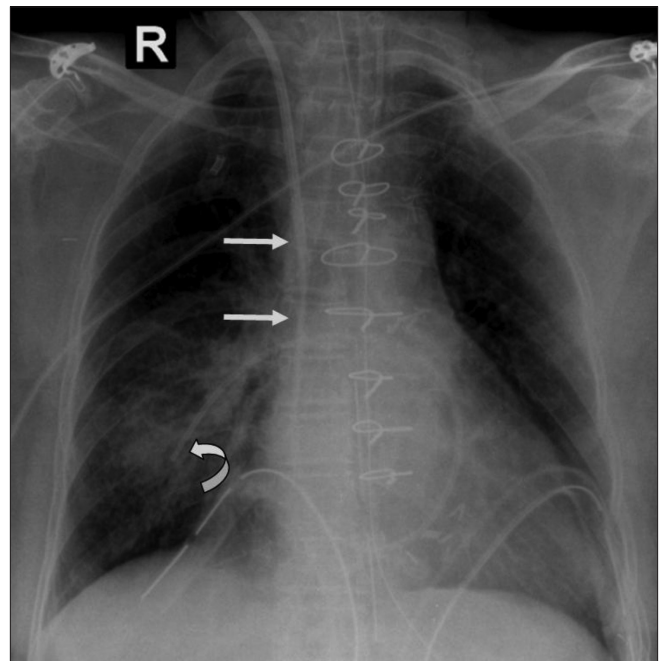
Frontal chest radiograph shows the tip (curved arrow) of a Swan-Ganz catheter (straight arrows) lying in the descending branch of the right pulmonary artery. The right paracardiac opacity is due to pulmonary infarction
